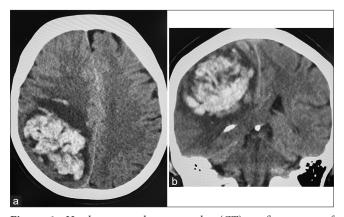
Head computed tomography (CT) at first onset of intracerebral hemorrhage. A hematoma 7 cm in size was found in the right parietal lobe in axial (a) and coronal (b) view.
